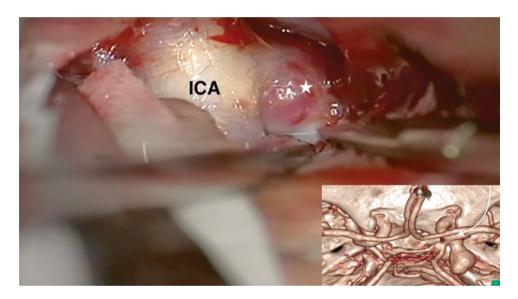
Unruptured posterior communicating artery (PCoA) segment of internal cerebral artery (*ICA*) aneurysm through right LSO approach. In the bottom right corner – 3D reconstruction of computed tomography angiography showing route to the aneurysm (*white arrow*). In the middle – exposed PCoA-ICA aneurysm (*white asterisk*)
